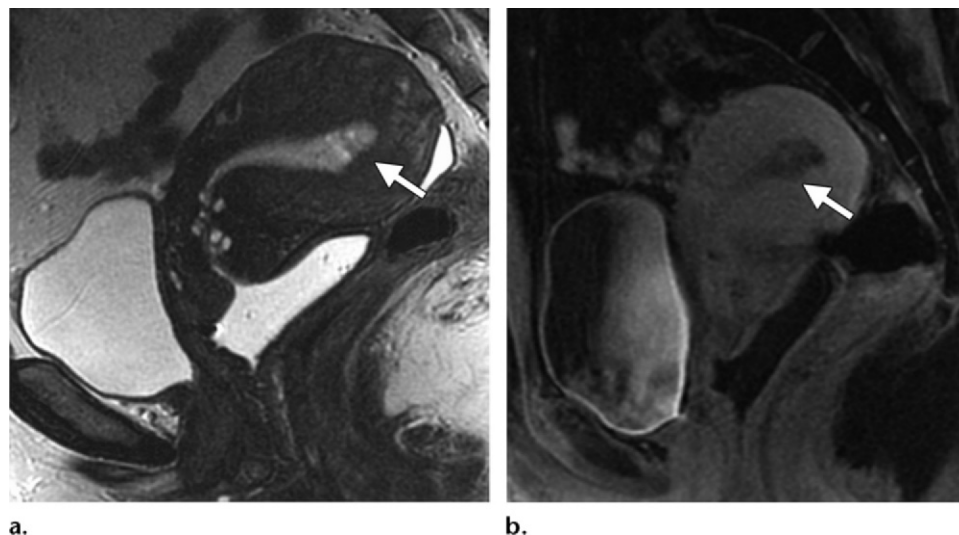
Value of contrast-enhanced T1-weighted images in assessing myometrial invasion. (a) Sagittal high-resolution T2-weighted FRFSE MR image shows a small endometrial mass in the uterine fundus (arrow). (b) Sagittal dynamic contrast-enhanced T1-weighted 3D FSPGR MR image obtained in the delayed phase (2–4 minutes after administration of contrast material) shows myometrial invasion along the posterior uterine wall (arrow) that is confined to the inner myometrium. Use of delayed contrast enhancement optimizes contrast between the myometrium and tumor.
